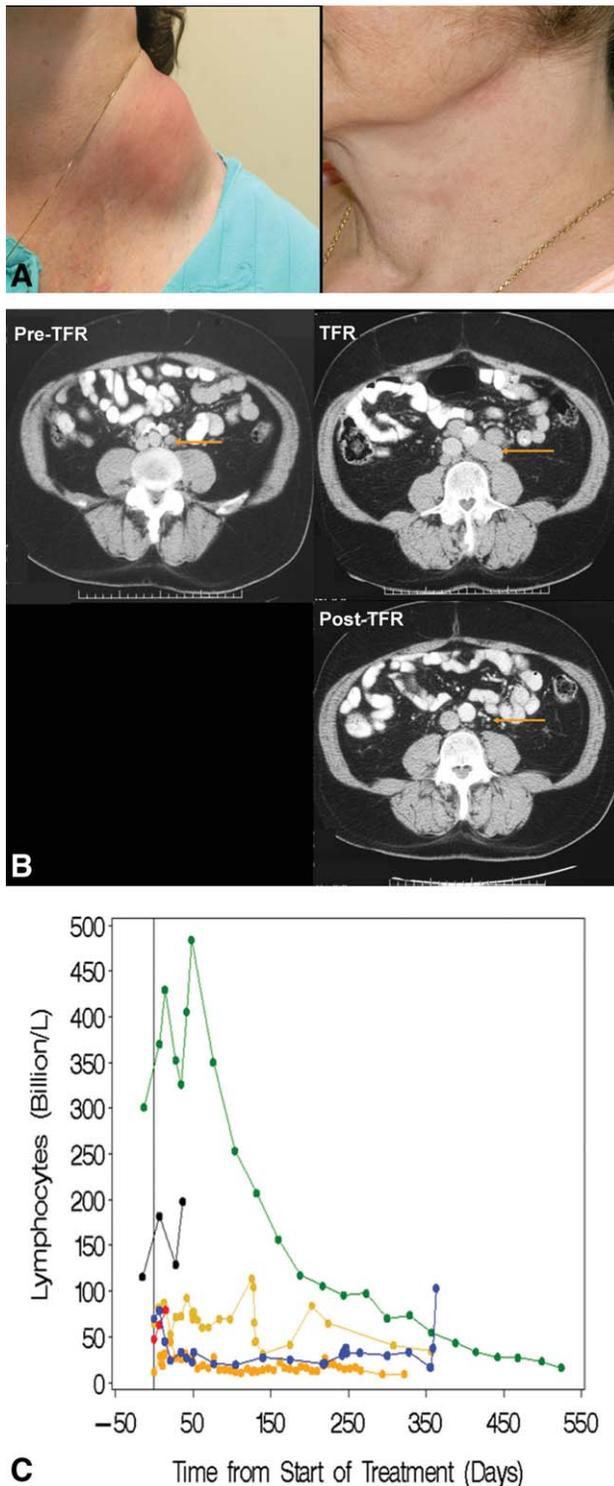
Clinical features of tumor flare reaction (TFR) are shown. (A) TFR manifesting as a tender increase in the size of a left cervical lymph node with overlying erythema after 7 days of therapy with lenalidomide is shown in a patient with chronic lymphocytic leukemia. The TFR resolved completely after 2 months with continued therapy. (B) TFR presenting as lower back pain because of a sudden increase in the size of retroperitoneal lymph nodes after 7 days of treatment with lenalidomide is shown. It completely resolved after continued treatment. The arrow identifies retroperitoneal lymph nodes noted on computed tomography scan at baseline (pretreatment), during TFR, and at the time of resolution. (C) In some patients, TFR can also present as an increase in the absolute lymphocyte count (ALC) in the peripheral blood. Six patients demonstrated an increase in peripheral blood ALC as a manifestation of TFR. Kinetics of ALC in the peripheral blood circulation of these patients is noted in this figure showing an initial increase in the ALC with lenalidomide treatment, which subsequently resolved with continued treatment.
